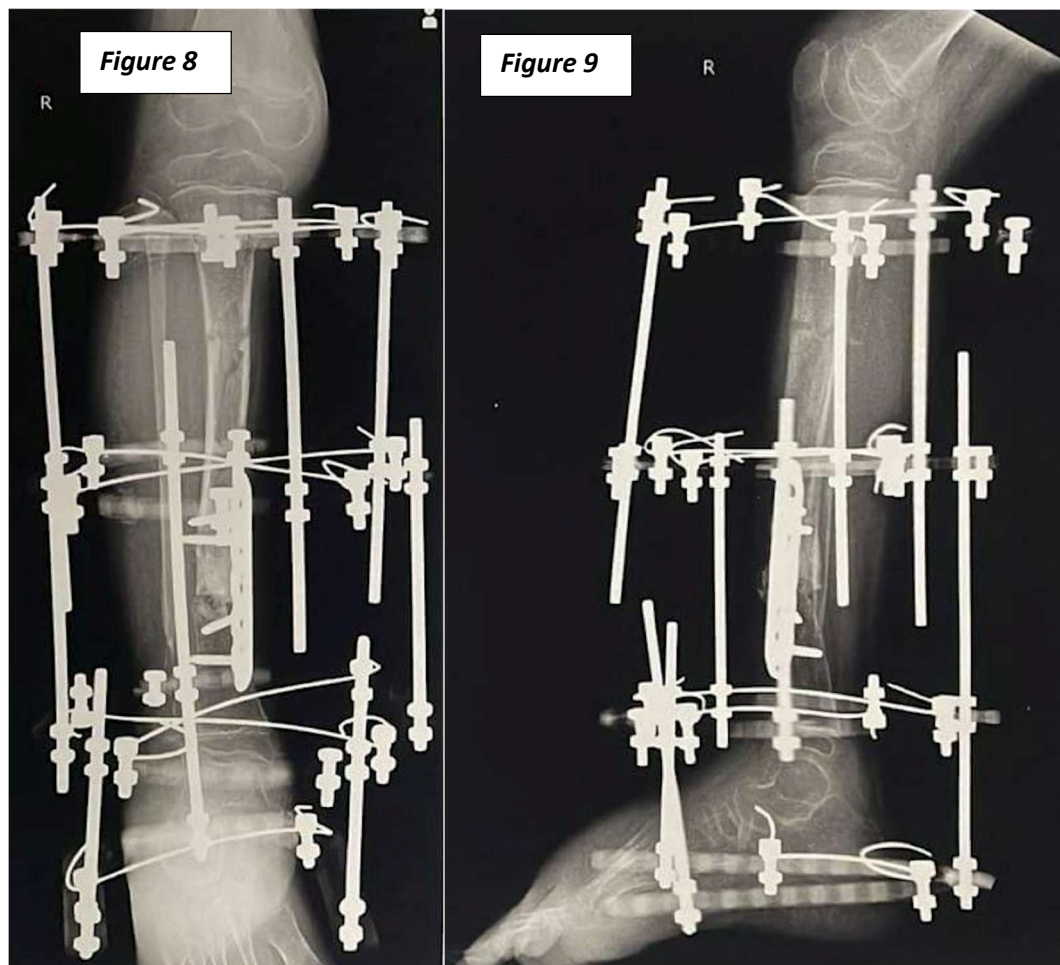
and 9 Shows 2 months follow up x-ray of the child showing uniting tibial shaft with plate and ilizarov fixator in situ with osteogenesis at corticotomy site in anteroposterior and lateral view respectively
